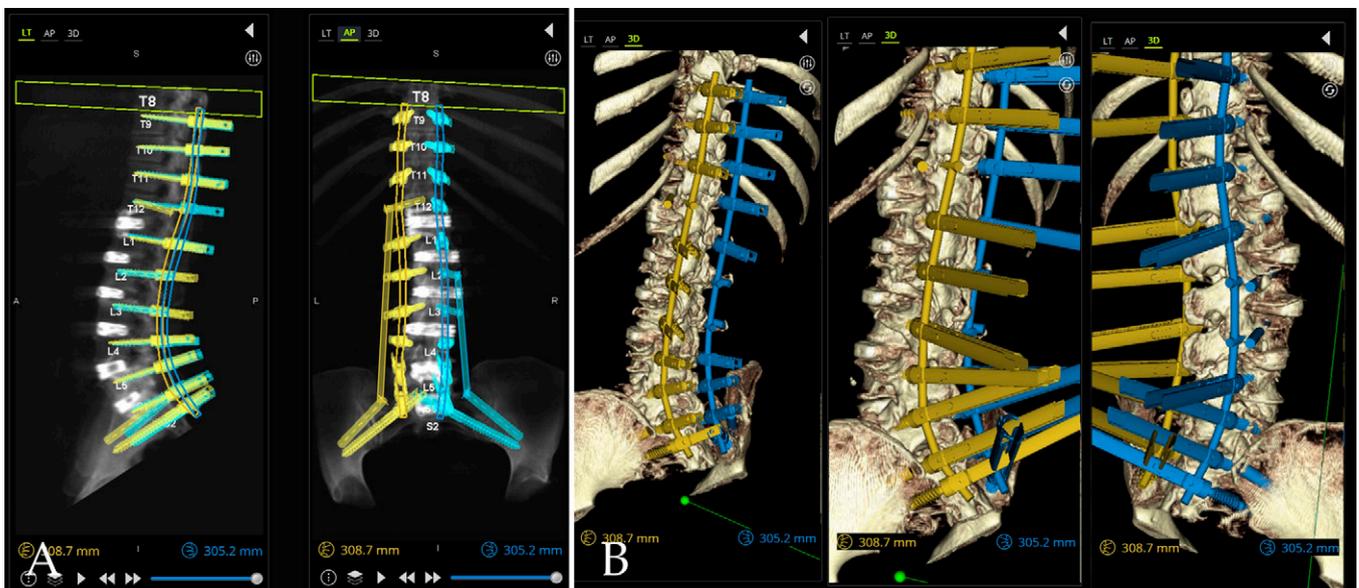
A: Predictive software plan compared with standing anteroposterior lumbar radiograph after the first-stage T12–S1 oblique lumbar interbody fusions. B: Predictive software plan compared with standing lateral lumbar radiograph after the first-stage T12–S1 oblique lumbar interbody fusions.
